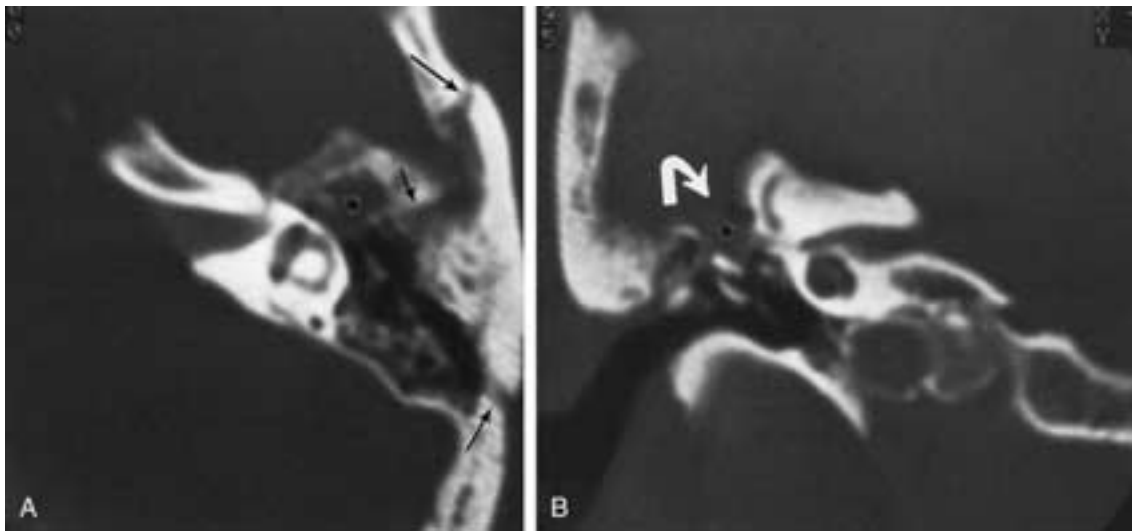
Complicated mixed fracture. A, Axial section. Fracture lines are demonstrated (arrows). A soft-tissue mass is identified in the attic (*). B, Coronal image. A large tegmen defect is present (curved white arrow). A soft-tissue mass is identified in the attic (*). This mass could represent encephalocele or cholesteatoma invading the fracture line. MR imaging was recommended.
